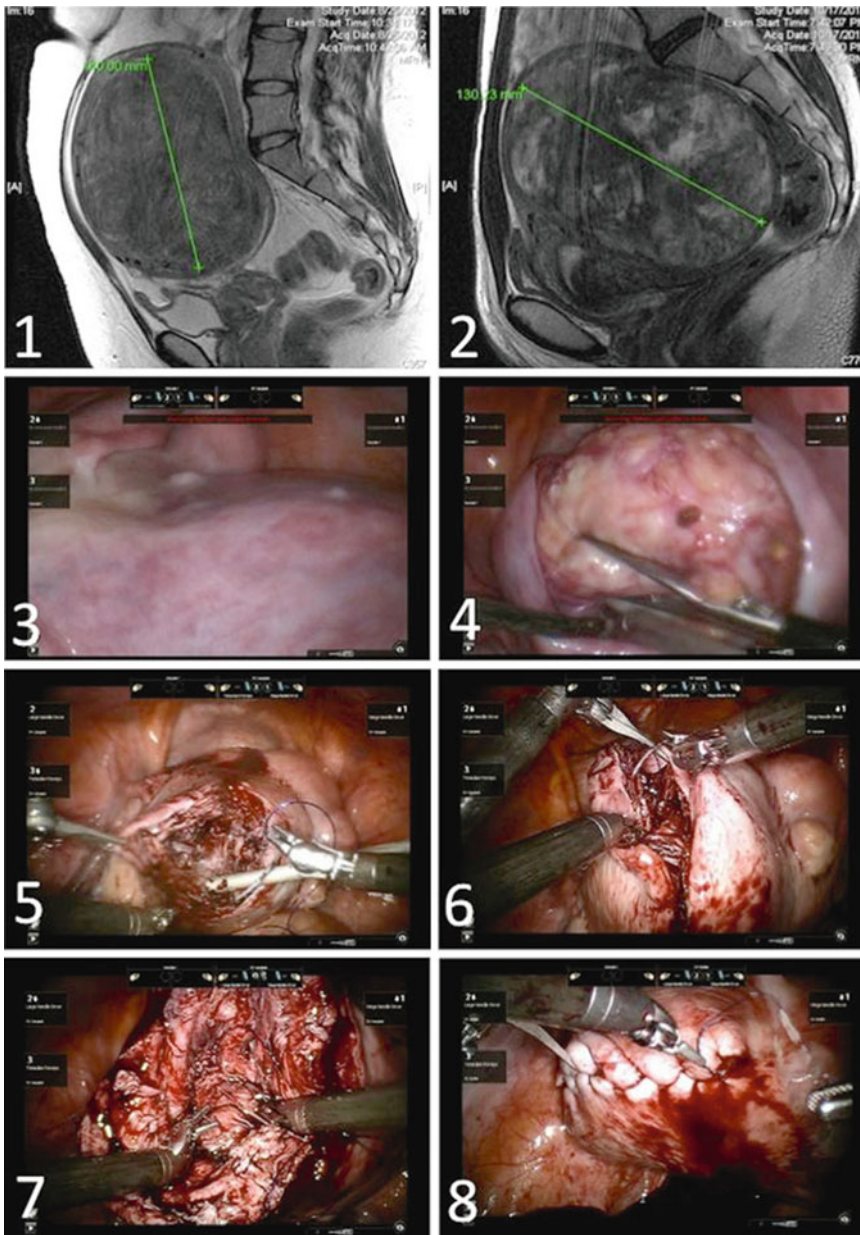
Hybrid robotic myomectomy. (1) and (2) show MRI images (T2-weighted sagittal projections) of typical surgical candidates for the hybrid RM variant at our center. Myomas in the 10–15 cm range are more effectively enucleated with this technique in our experience. (3) Standard laparoscopic camera is used to guide enucleation. (4) The surgeon creates a transverse incision over the myoma using a harmonic scalpel; the 10-mm laparoscopic tenaculum is used to manipulate the fibroid during
